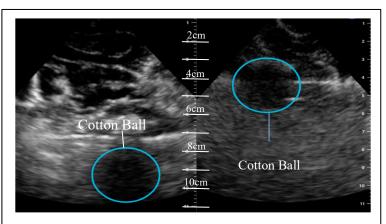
The image on the left is a cotton ball at 8cm deep in the brain. The image on the right is a cotton ball at a depth of 3cm. Cotton is distinguishable at a multitude of depths in the brain, with ultrasound being able to detect cotton at least 8 cm deep.
